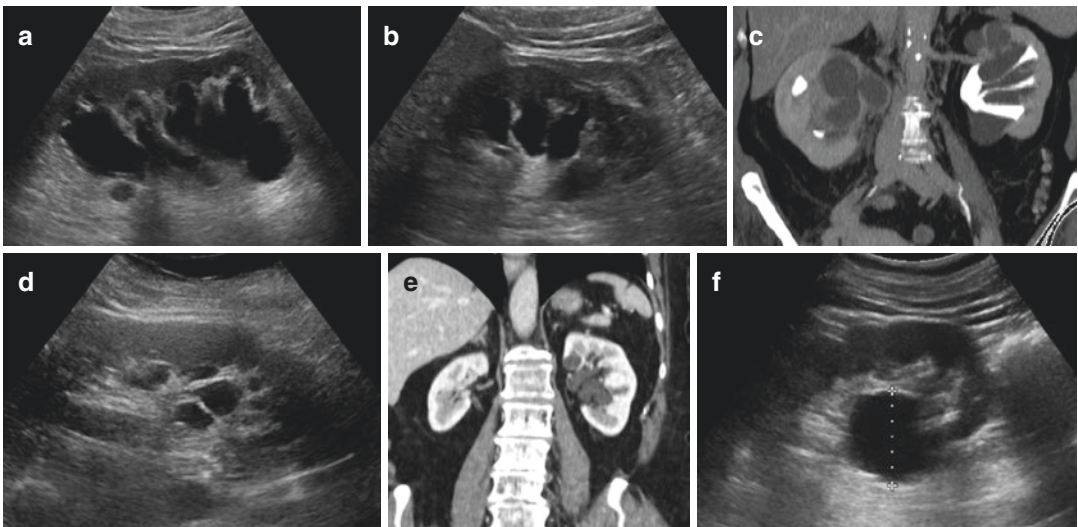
(a, b) Peripelvic cysts (elongated cystic formations in the medullary). (c) Straining of the calyceal structures due to the resting of the cysts. (d, e) Multiple peripelvic cysts in US and CT coronal view. (f) Single parapelvic cyst
